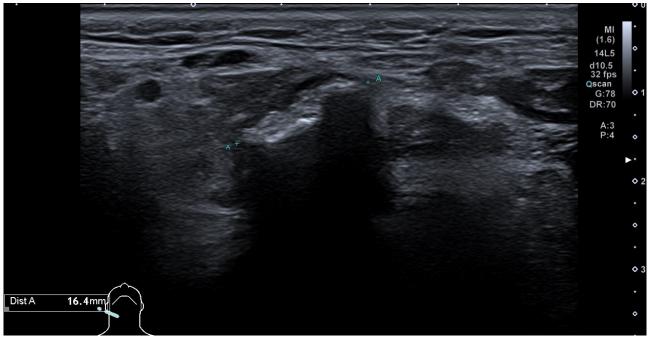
Hyperechoic reflection seen on ultrasound caused by a deposit in the parotid duct (sialolithiasis).
